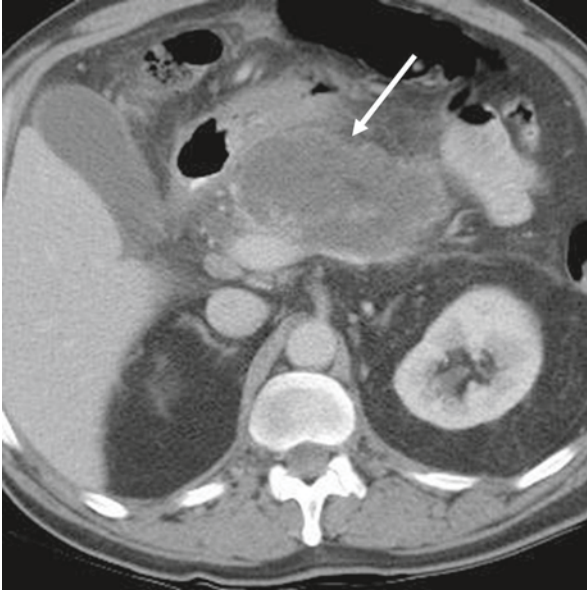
Computed tomography of the abdomen revealing walled-off pancreatic necrosis (*arrow*)
